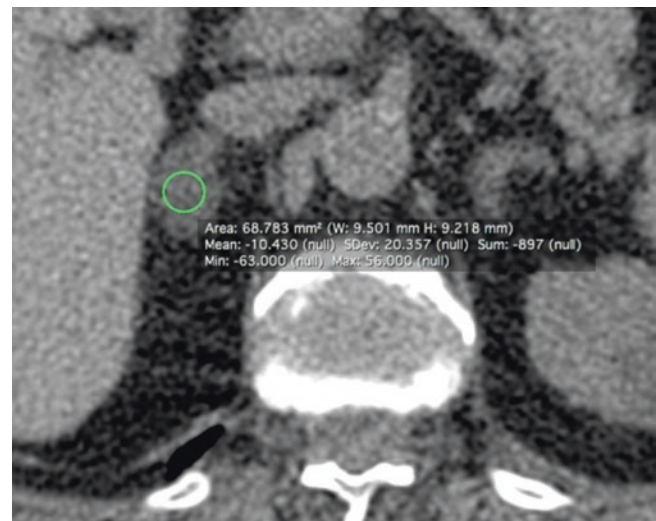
Right adrenal adenoma. CT without IV contrast depicting an elongated hypodense adrenal mass with attenuation coefficient of -10.4 Hounsfield units
